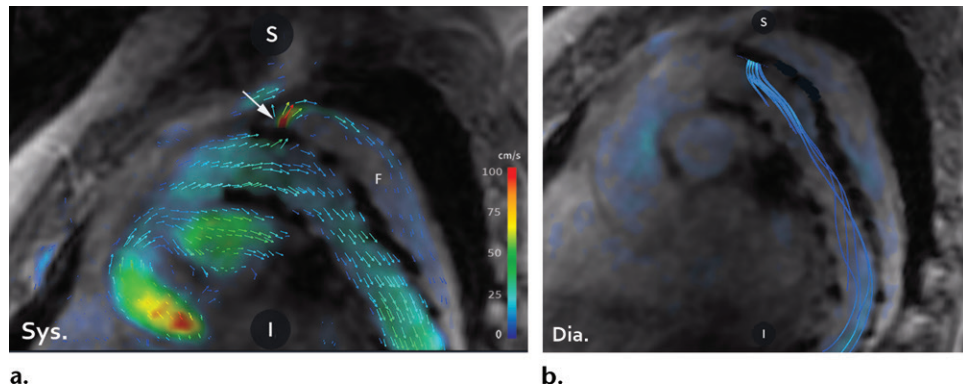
Type I endoleak shown by 4D flow MRI in a patient with a thoracic stent-graft after type B aortic dissection. (a) Image with velocity vectors shows the inflow course of the type I endoleak (arrow) within the false lumen (F). Sys = systole. (b) Image with streamlines shows outflow back to the aortic lumen during diastole (Dia) owing to higher pressure in the false lumen.
